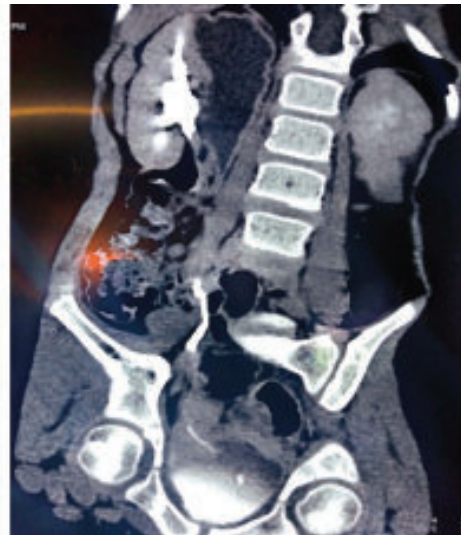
Multiplanar urogram-phase CT serial images coronal view shows dilatation of the upper moiety with thin cortex and no contrast enhancement on right. Dilated upper-polar ureter .
